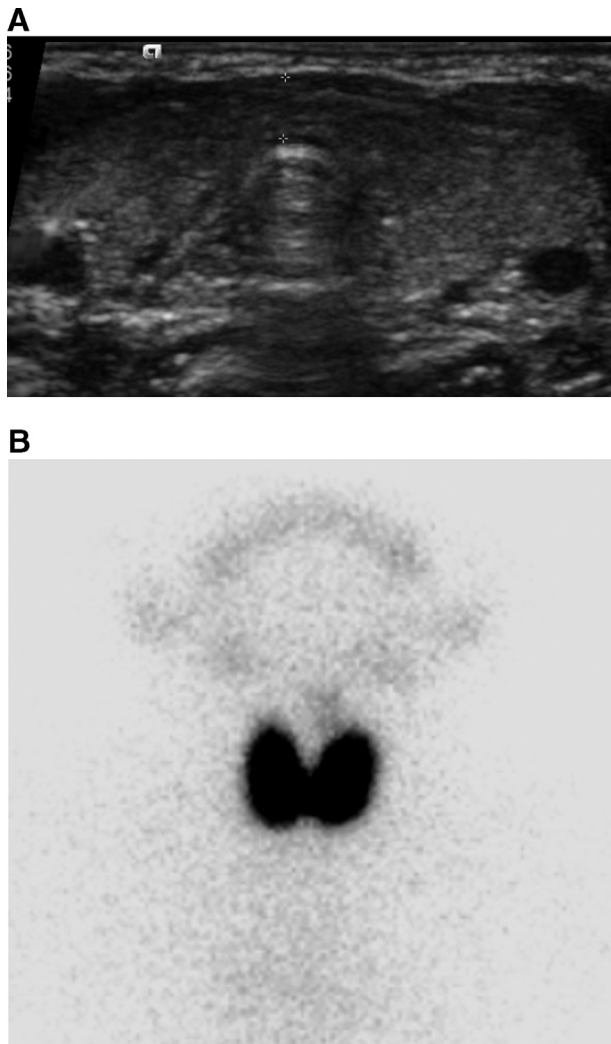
Thyroid dysmorphogenesis in 2 patients with abnormal congenital blood spot screening. A. Transverse gray scale ultrasound image in a 12-day-old girl shows an enlarged thyroid gland. B. Tc99m pertechnetate radionuclide scintigraphy on frontal projection in a 6-week-old girl shows increased thyroid uptake.
